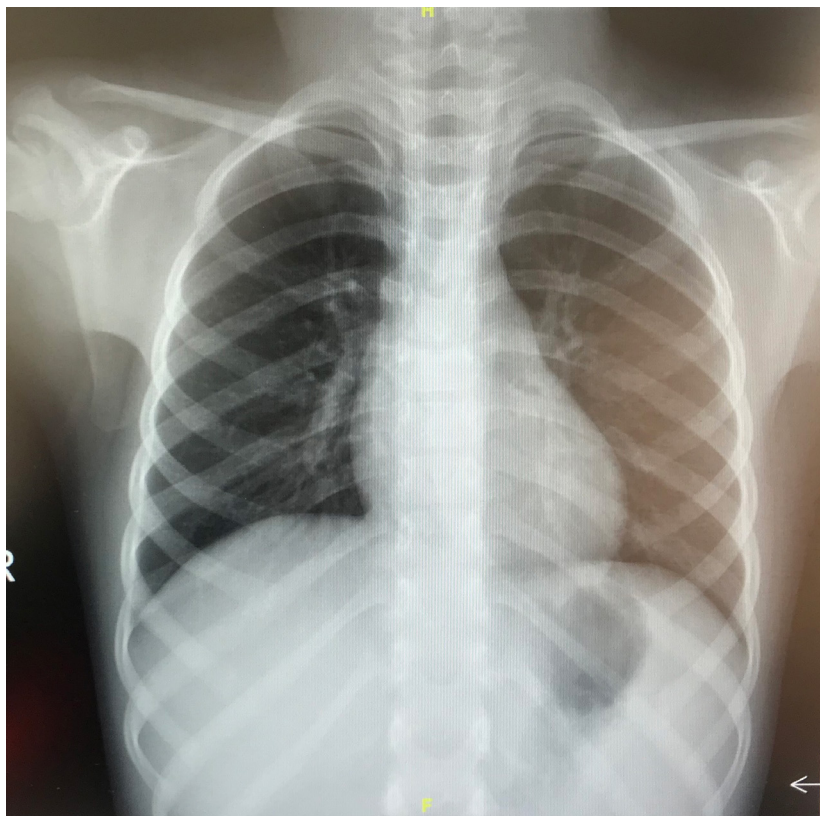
Chest Radiography
